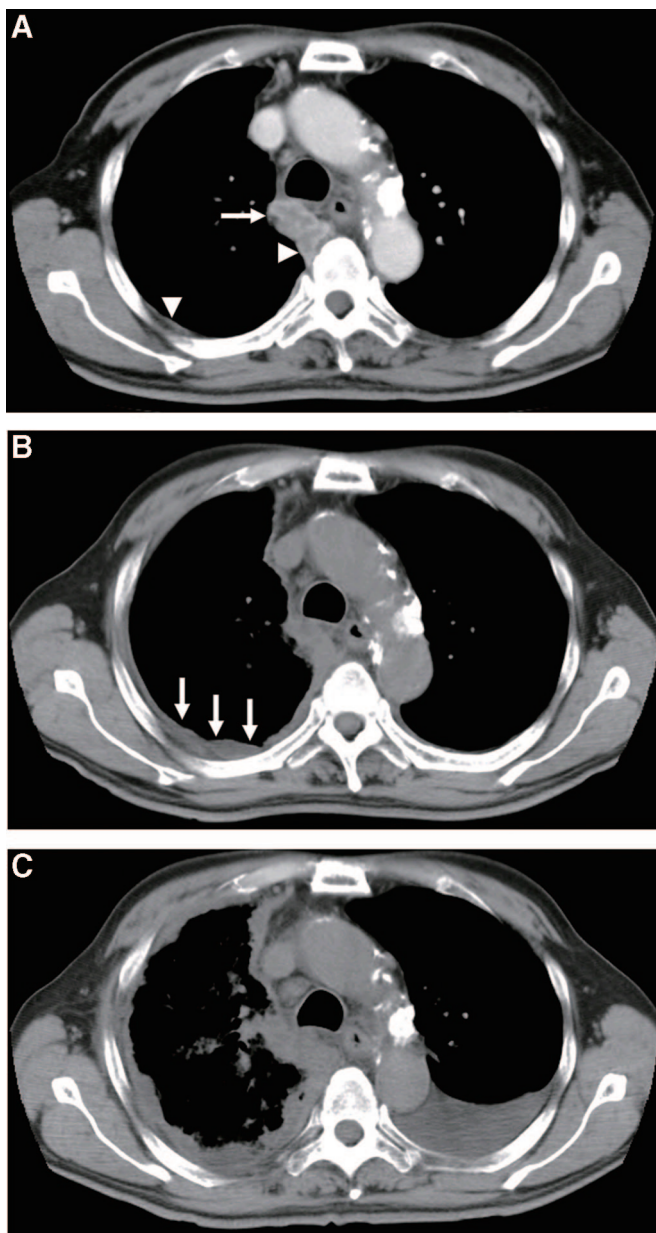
Chest computed tomography scan images. (A) Enhanced image (August 16, 2006) showing a slightly enlarged pos-tracheal lymph node (*arrow*) and partial thickness of the right pleura (*arrowheads*). (B) Image (August 21, 2006) showing the growth of pleural thickness (*arrows*). (C) Image (August 24, 2006) showing circumferential pleural thickness and left pleural effusion.
